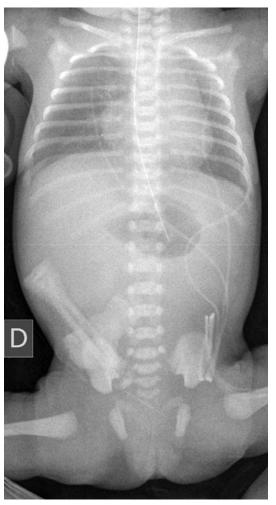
Abdominal x-ray at birth confirming intestinal obstruction.
